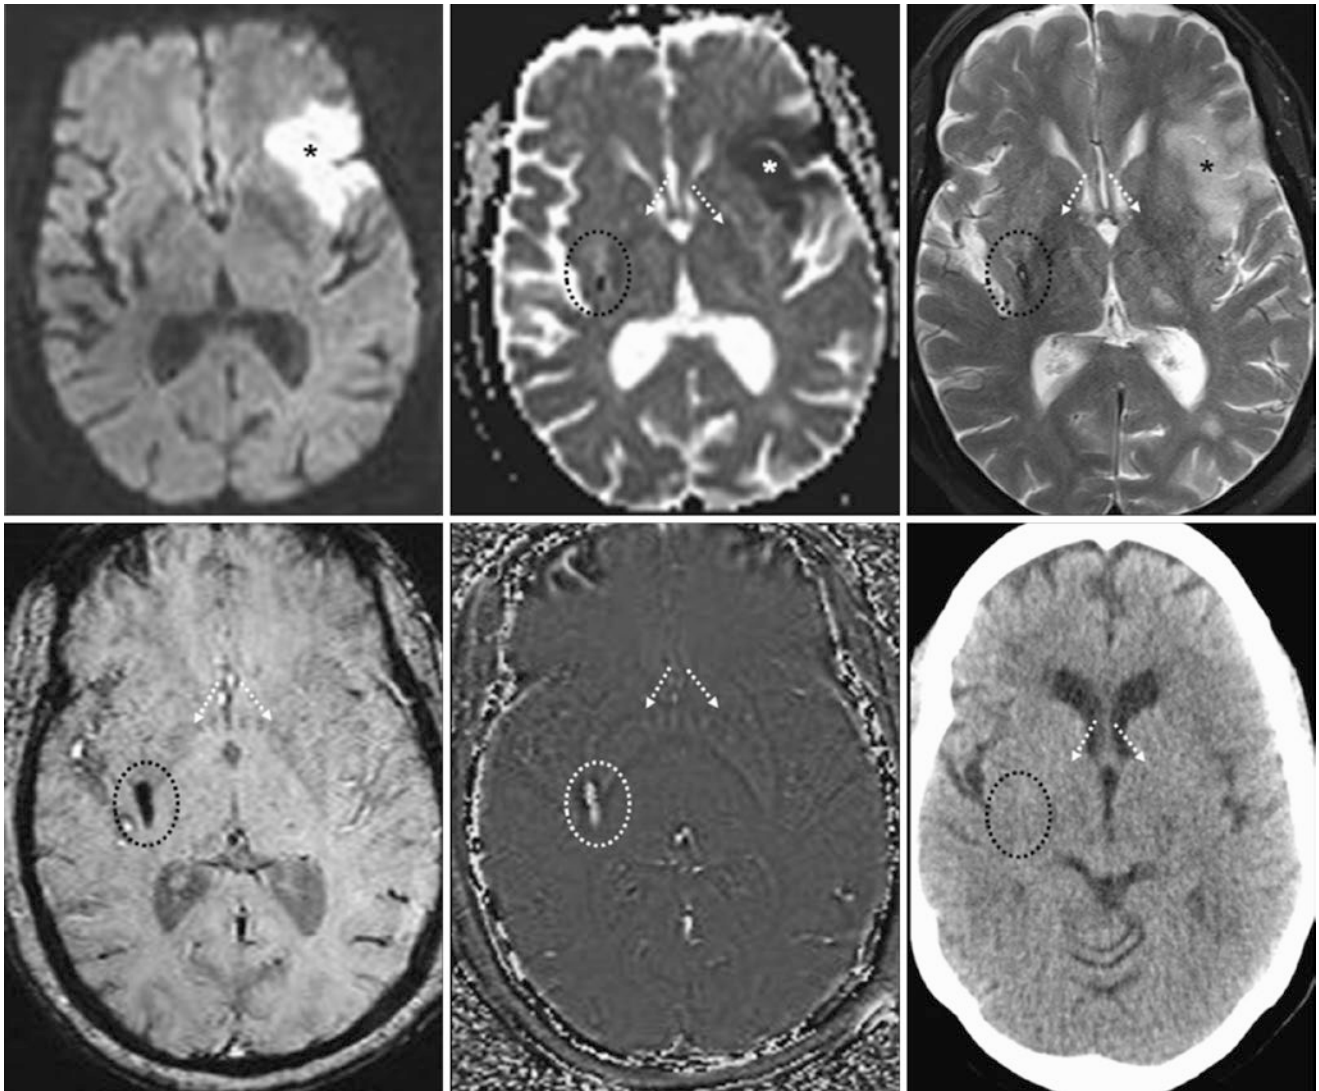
Comparison case: acute stroke and hemosiderin. A 73 year old had an acute left MCA infarct (*) on 1.5T DWI MRI (*top left*), ADC map (*top middle*), and T2WI (*top right*). SWI (*bottom left*) also showed focal dark signal within the contralateral right putamen (*dotted circles*), with only scant iron deposition of the GP (*dotted arrows*). There was no
